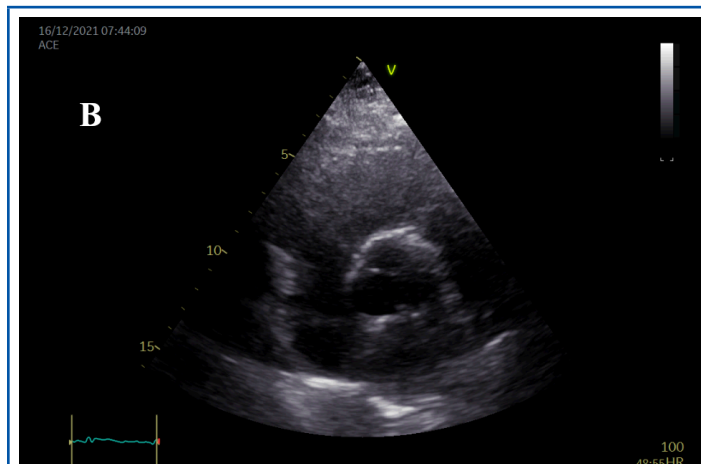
Postoperative 2D-transthoracic echocardiography. Parasternal short axis view confirms successful aortic thrombus resection with preserved integrity of the aortic valve and wall.
